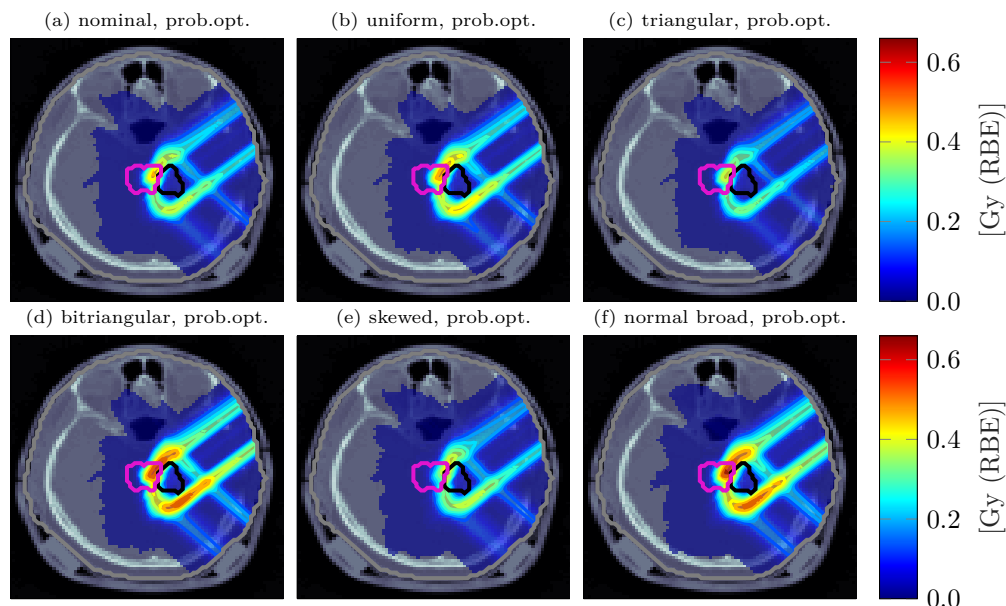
Uncertainty quantification result on the basis of probabilistic optimization. Transversal CT image close to the iso-center of the intra-cranial case superimposed by transparent dose colorwash indicates the standard deviation of the RBE-weighted dose on the basis of various PDFs.
